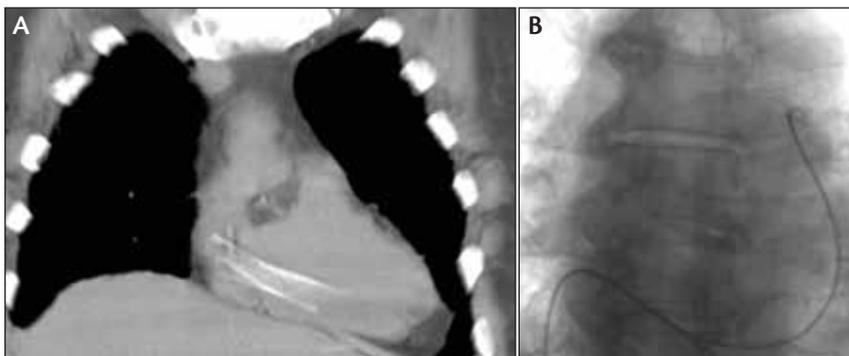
Intracardiac migration of a self-expanding nitinol stent. A coronal CT reconstruction shows the stent lying across the tricuspid valve (A). Cardioversion was administered by an eager cardiologist because of ventricular tachycardia caused by attempts to capture the stent in the right atrium, and the stent migrated to the pulmonary artery as a result. This made capture of the stent much easier, but if the procedure had failed, subsequent surgery would have been more complicated. Using a simple loop snare, the stent was captured near one end (B) and moved gently to the IVC. The tricuspid valve should be treated with great care to avoid damage to the valve and subsequent tricuspid incompetence.
